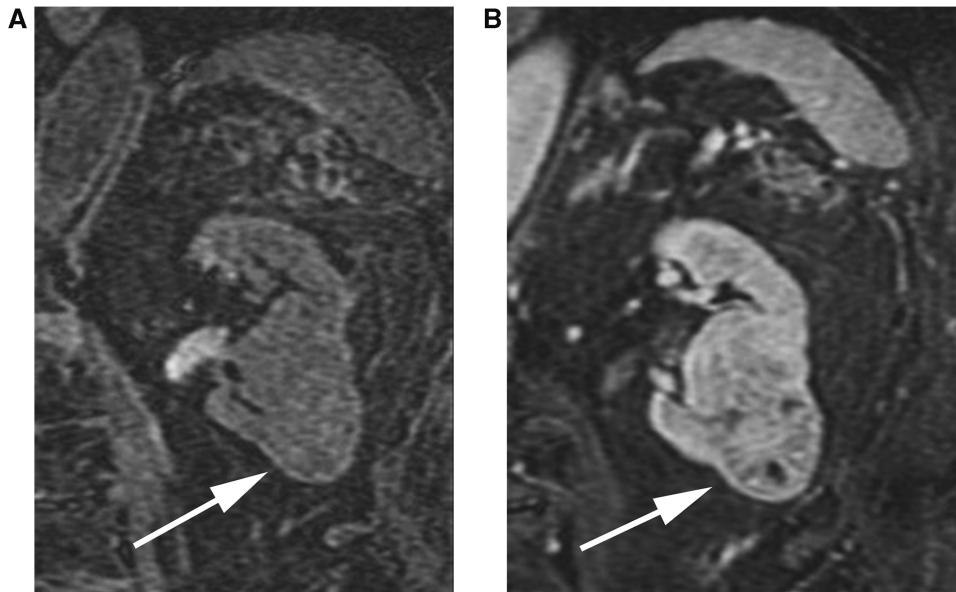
Oncocytoma. Coronal pre- (a) and post-contrast (b) enhanced T1-weighted images shows an enhancing mass (arrows) which has a non-specific appearance.
